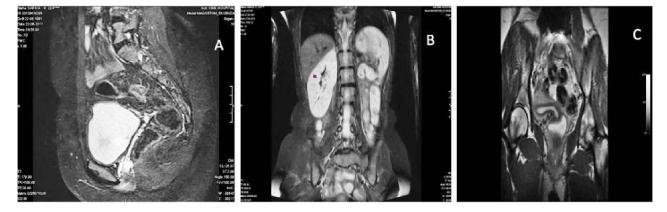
MRI image of uterine agenesis A: Uterine agenesis B: Left kidney not visualised C: MRI shows development of right cornua, of the uterus, left cornua absent, left kidney not visualized
